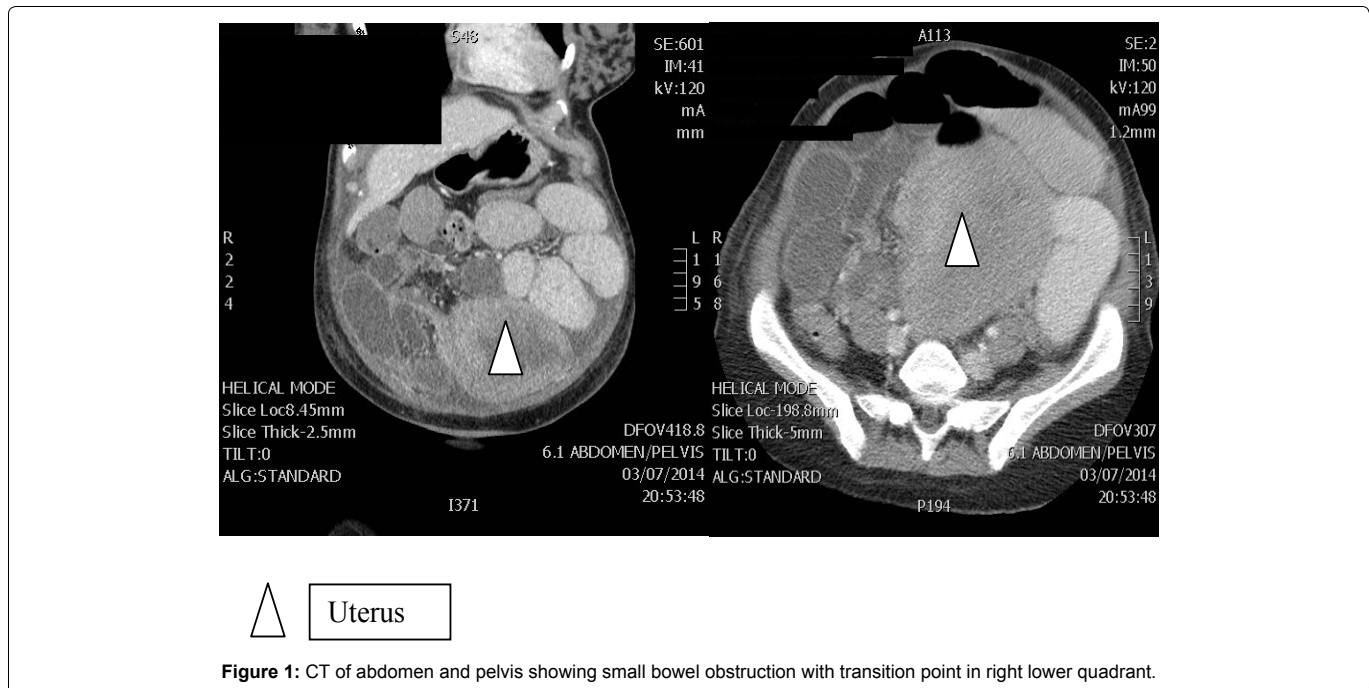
CT of abdomen and pelvis showing small bowel obstruction with transition point in right lower quadrant.
